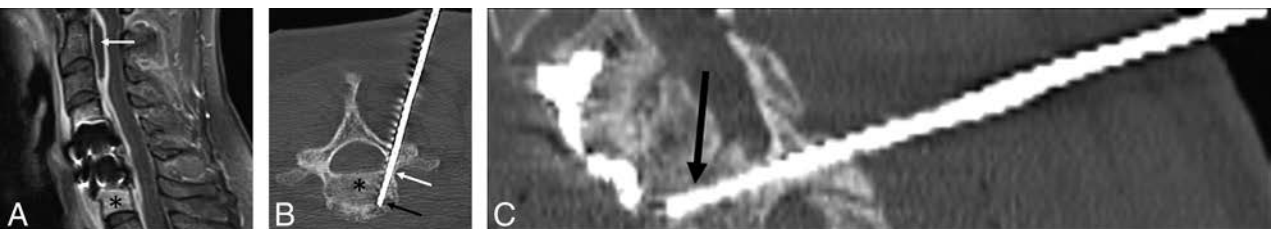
A 51-year-old woman with prior discectomy and interbody fusion. A, Sagittal T1 fat-suppressed postcontrast MR image with evidence of osteomyelitis at C7 (black asterisk), prevertebral inflammation, and epidural abscess (white arrow). Intraprocedural oblique axial (B) and oblique sagittal (C) CT reconstructed images during the biopsy procedure show the biopsy needle placed from a posterolateral approach, through the right C7 pedicle (white arrow) into the vertebral body (black asterisk) and subsequently the C6–C7 disc space (black arrow). Microbiology grew *Staphylococcus aureus*, and pathology showed osteomyelitis.
